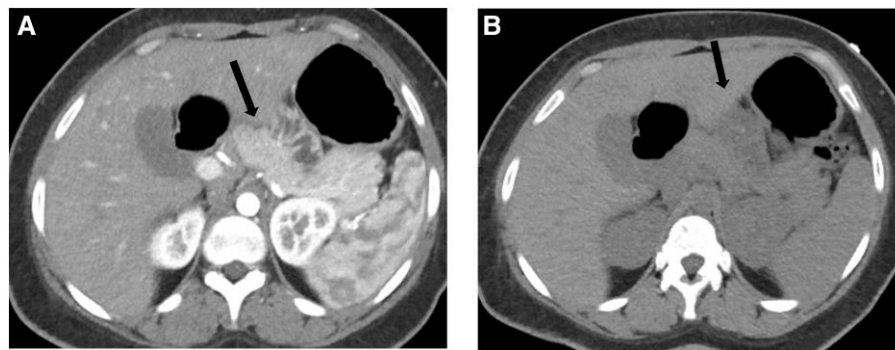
CT pancreatic protocol with (A) and without contrast (B). Black arrow is pointing out the pancreas.
